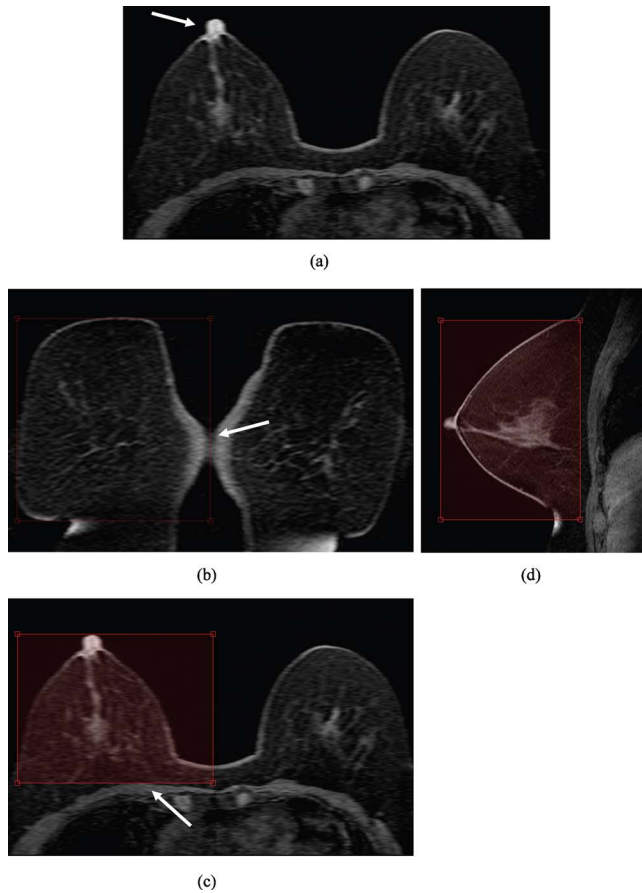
The bounding box in three views for the MRI breast region. (a) The nipple is indicated by the arrow in the transverse view. (b) The lateral boundary of the breast is determined by the bounding box in the coronal view. The arrow indicates the minimum connected region of the two breasts which could separate the two breasts. (c) The segmented breast is determined by the bounding box and the pectoralis muscle is indicated by the arrow in the transverse view. (d) The segmented breast is determined by the bounding box in the sagittal view.
